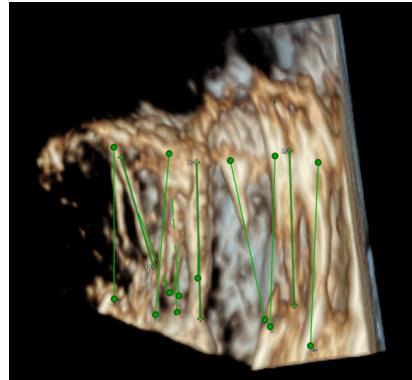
Segmentation of the visible chordae tendineae from 3D ultrasound images by distance measurements from their attachment point at the mitral valves to their attachment point at the papillary muscles.
